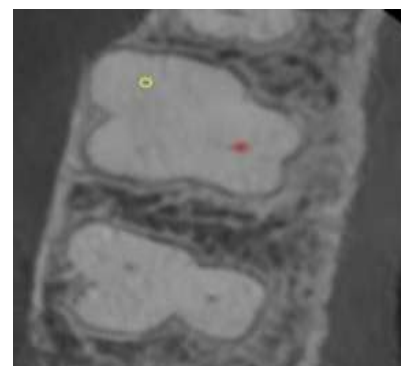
Preoperative IOPA radiograph (1a) and CBCT scan (1b, 1C) with tooth #16
